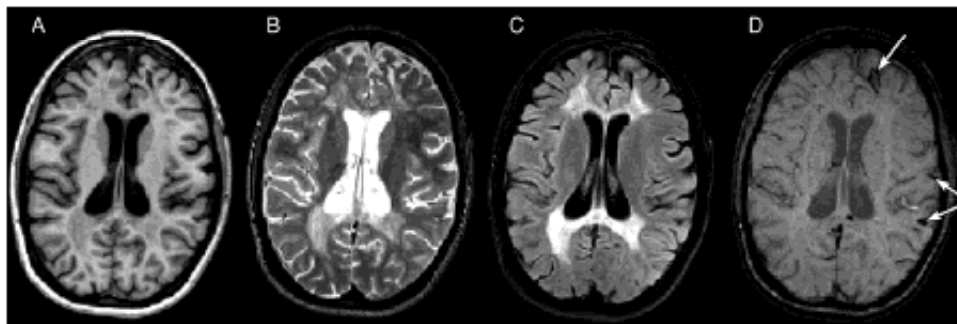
As shown in Table 2.1, each imaging sequence shows unique findings of normal and abnormal brain tissue signal intensity at the same level in the brain in the same individual. (A) T1; (B) T2; (C) FLAIR; (D) SWI. This patient had sustained a severe TBI with each sequence demonstrating unique morphological and pathological findings. For example, note that the T1 and SWI sequences do not demonstrate the white matter changes shown in the T2 and FLAIR. In contrast, note how large the frontal hemorrhagic lesion is in the SWI sequence shown in (D); while detected in the other imaging sequences, the size is substantially smaller.
